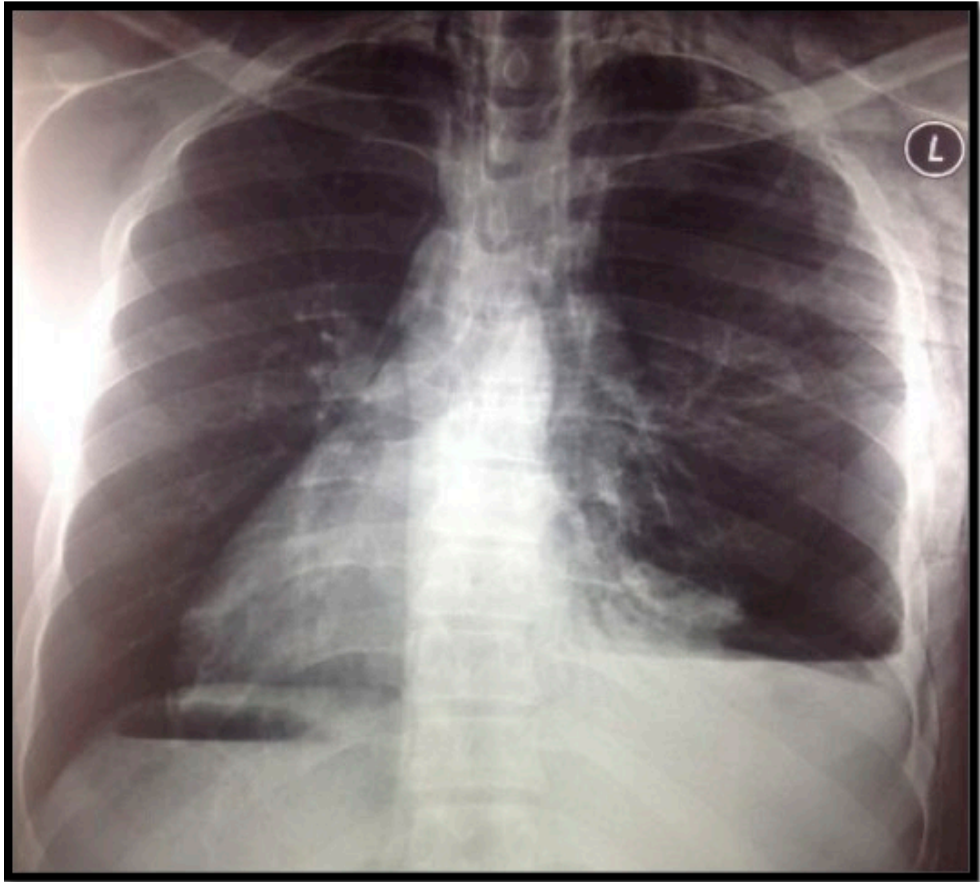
Chest X-ray (posteroanterior view) showing left hemo-pneumothorax.
